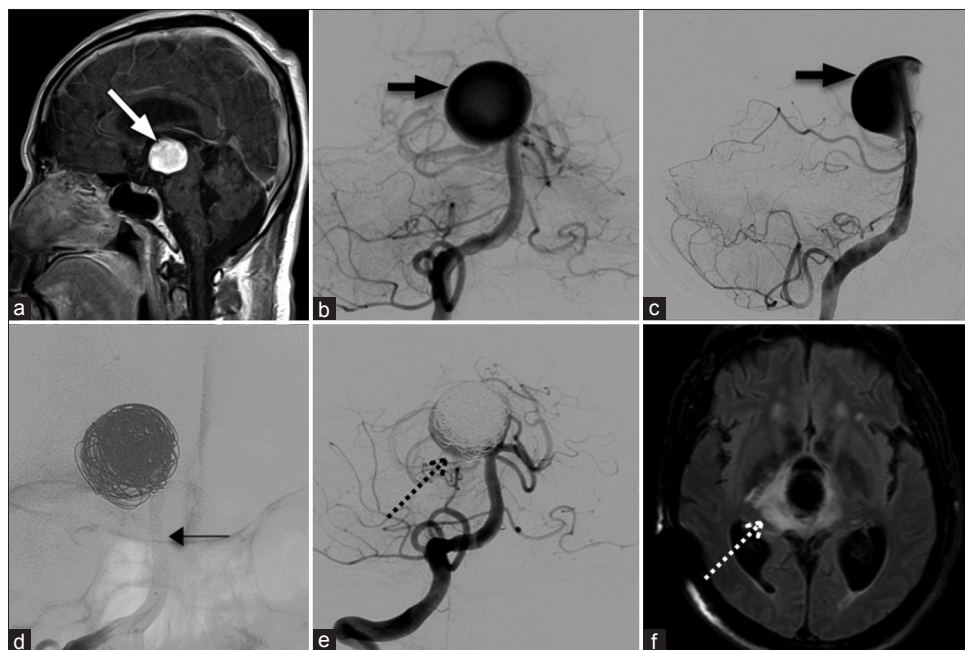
A 65-year-old male with headache. (a) MRI showing an aneurysm (thick white arrow). (b and c) Right VA angiogram showing a large basilar tip aneurysm (thick black arrow). (d) Flow diverter stenting with coil (thin black arrow). (e) Angiogram showing incomplete obliteration (black dot arrow). The patient developed drowsiness 1 week after. (f) MRI showing abnormal high signal intensity in the brainstem around the coil mass (white dotted arrow), likely resulting from inflammation by using bioactive coils. MRI – Magnetic resonance imaging; VA – Vertebral artery
